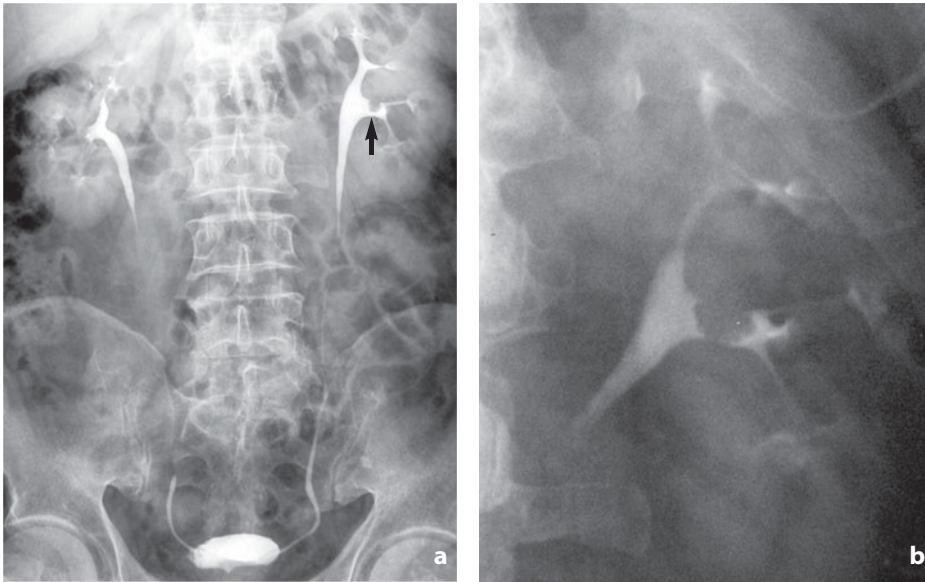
Urography. Transitional cell carcinoma. a Radiograph performed at end perfusion. At the level of the upper pole calices a round filling defect can be appreciated with attachment to the major calix wall (*arrow*). b Detailed radiography. Lesion with attachment to pelvic wall is confirmed, with lobulated margins and absent caliceal retrodilatation
